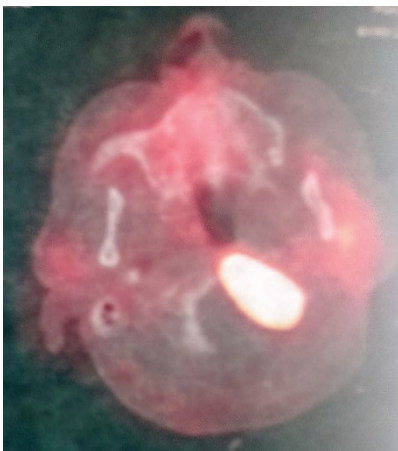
Somatostatin receptor positron emission tomography (PET-CT) scan showing a tumour in the left jugular foramen region involving posterior skull base and part of occipital condyle
